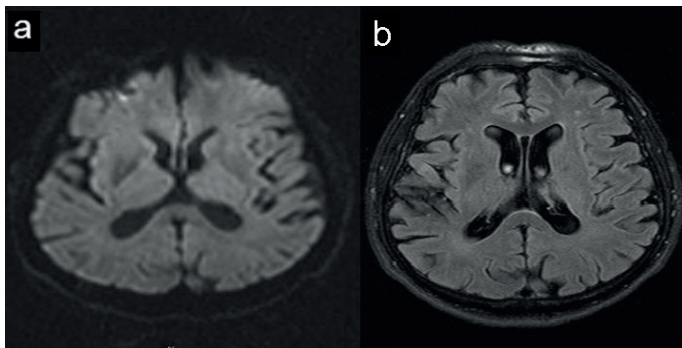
Axial diffusion (a) and FLAIR (b) sequences of the brain MRI does not show any signal changes supporting CJD.
